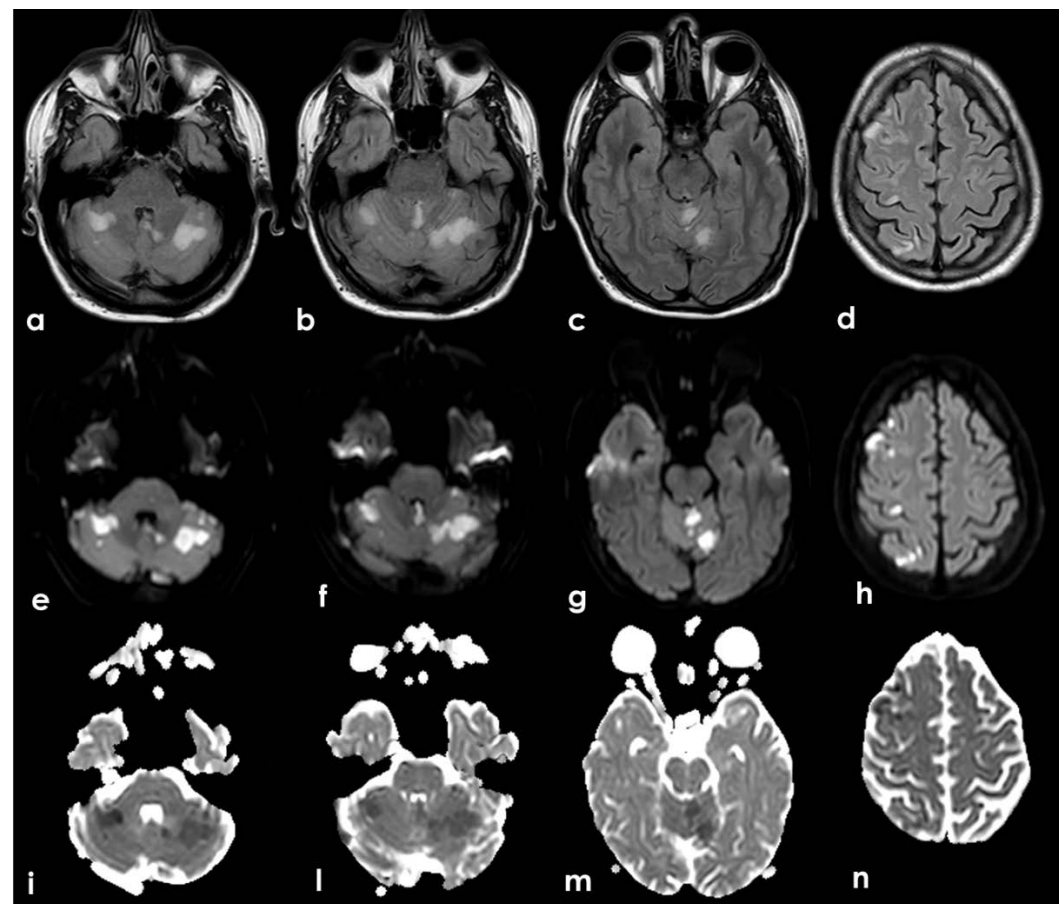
Brain MRI. Axial Fluid Attenuated Inversion recovery sequences (a-d) and the corresponding Diffusion Weighted Imaging (DWI) (e-h) and Apparent Diffusion Coefficient (ADC) images showing multiple recent ischemic lesions in cerebellar hemispheric white matter and vermis and in frontal and parietal right cortex with involvement of the cortical-subcortical junction. All the areas of signal change are hyperintense on FLAIR and DWI sequences and hypointense on ADC and these features are coherent with the ischemic nature and the subacute timing.
